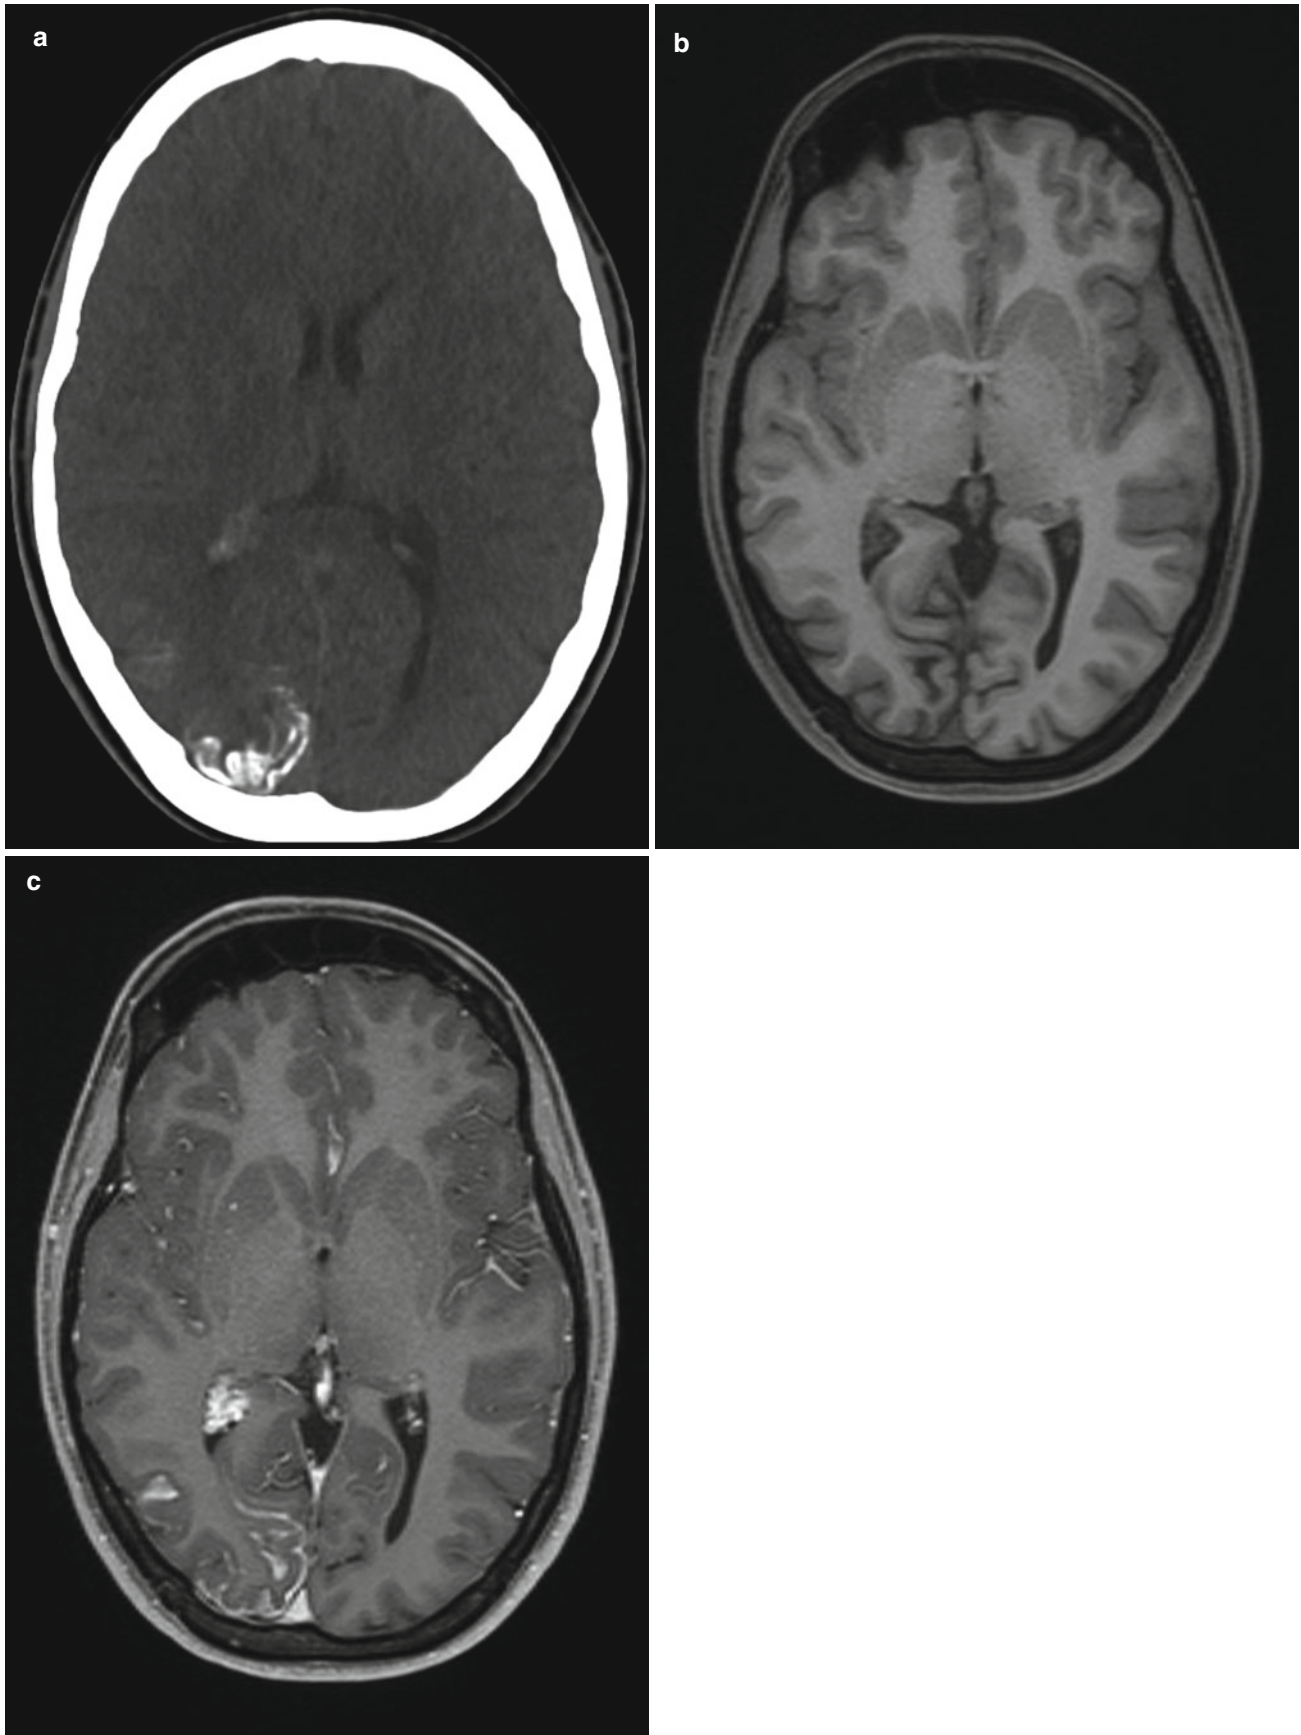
(a–c) Sturge-Weber syndrome; (a) axial CT shows curvilinear cortical calcifications in the right occipital lobe; (b) axial T1 without and c: with gadolinium shows contrast enhancement caused by pial
